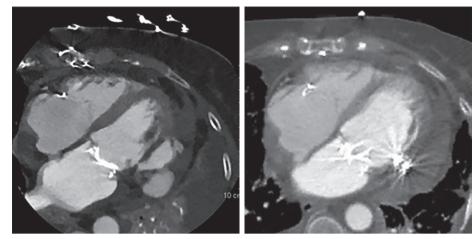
Left: image before the procedure (unsealed defect). Right: computed tomography imaging after Amplatzer device implantation.
